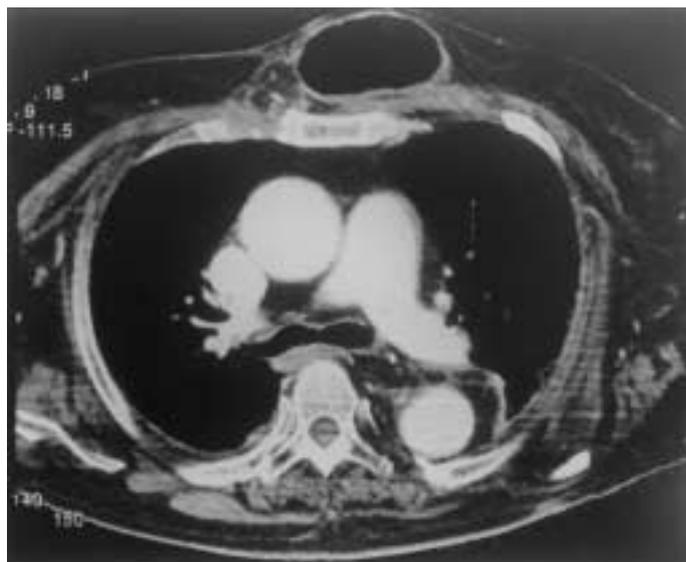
Enhanced CT showing the pre-sternal reconstruction of the esophageal truck.
